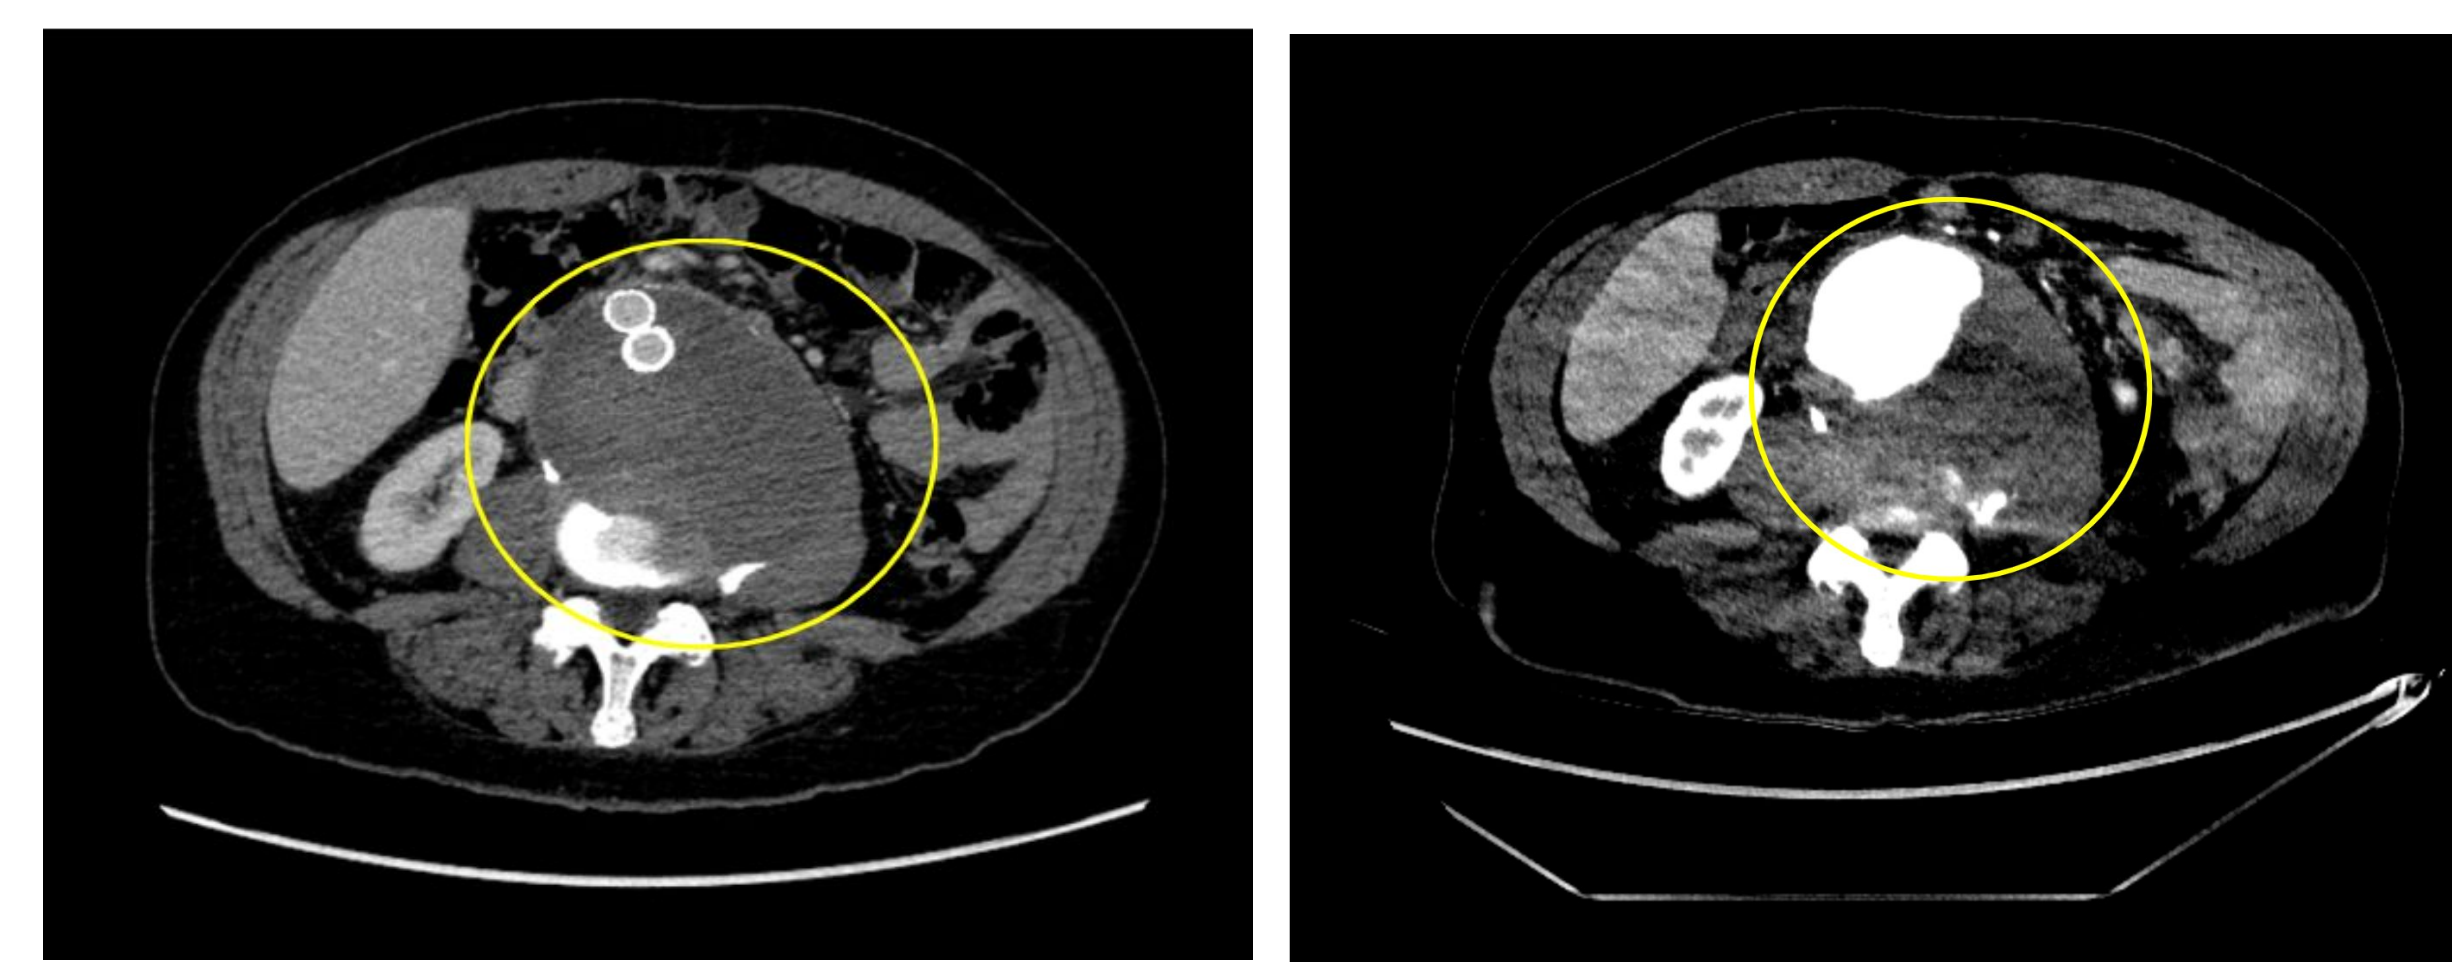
10.6 x 8.7cm infrarenal abdominal aortic aneurysm confirmed with CT Angiography
